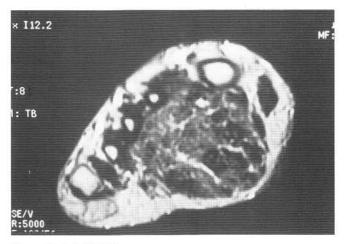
Axial MRI image.
